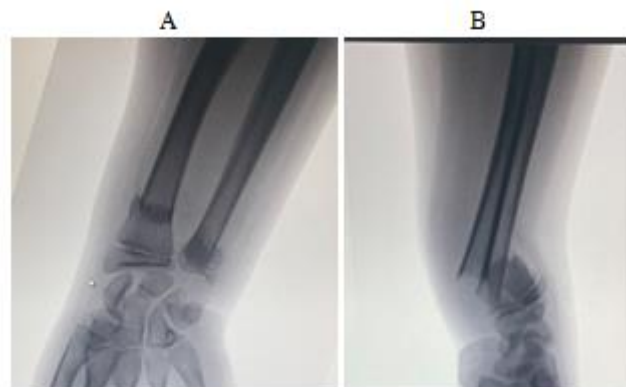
AP (A) and Lateral (B), an initial X-ray of the fracture
